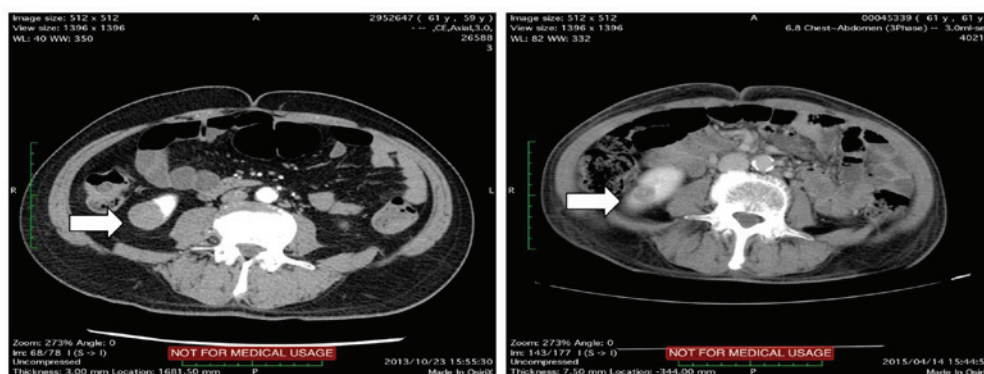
Case 6: Computed tomography revealed that, although the renal lesion was reduced, the bone metastatic lesion exhibited progression (left panel, pretreatment; right panel, post-treatment).
